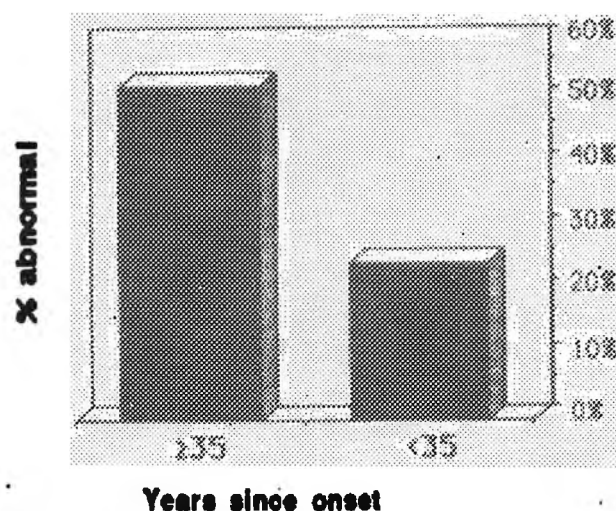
Radiographic findings and time since Board of Education hire among custodians with exposure to asbestos only in New York City schools.
